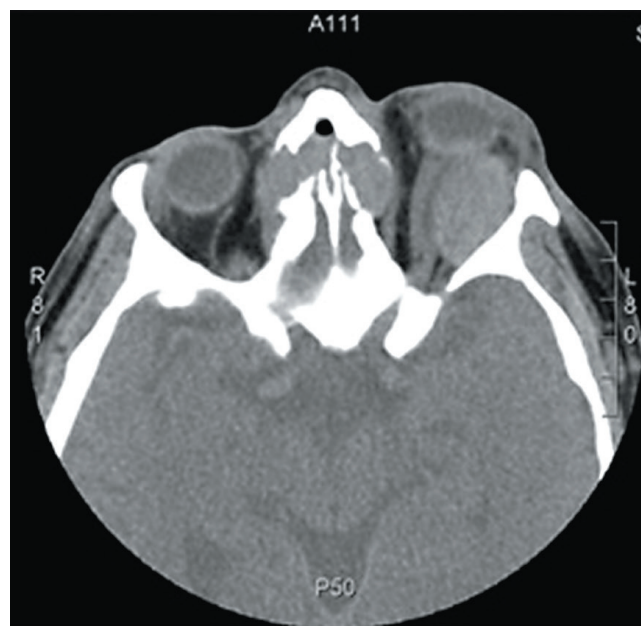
2. Contrast-enhanced computed tomography scan of paranasal sinuses and orbits with inflammation of tissues within the left orbit: left orbit abscess sized 20x30x34 mm causing significant compression and dislocation of orbital structures, including compression and forward as well as bottom left displacement of the left eyeball.
